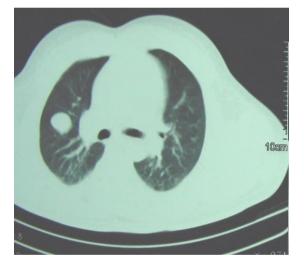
CT scan chest lung window showing an uncalcified mass in posterior segment of right upper lobe.
